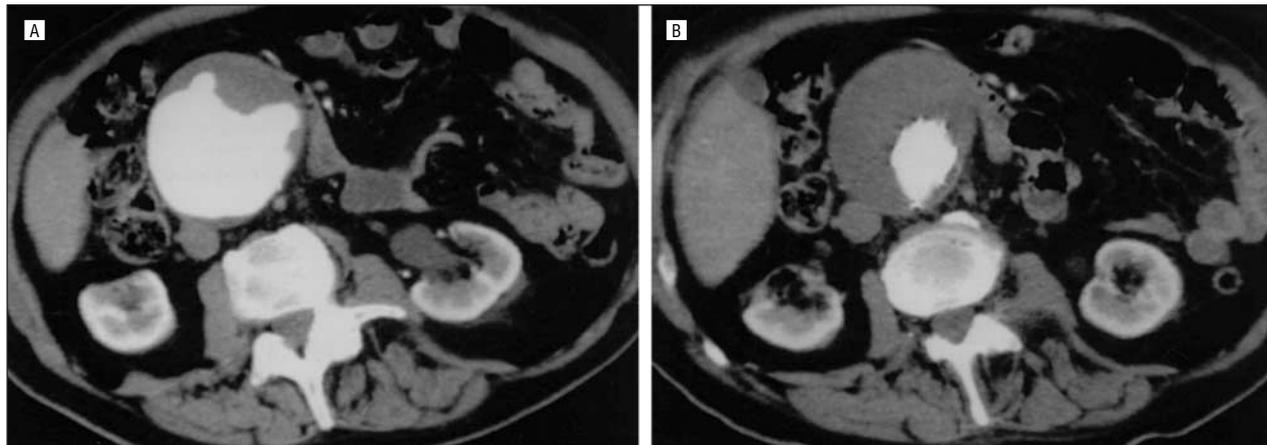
A, Preoperative computed tomography results from an 86-year-old patient with a 9-cm infrarenal abdominal aortic aneurysm. B, Computed tomography results from the same patient, 1 month following successful endovascular repair.
